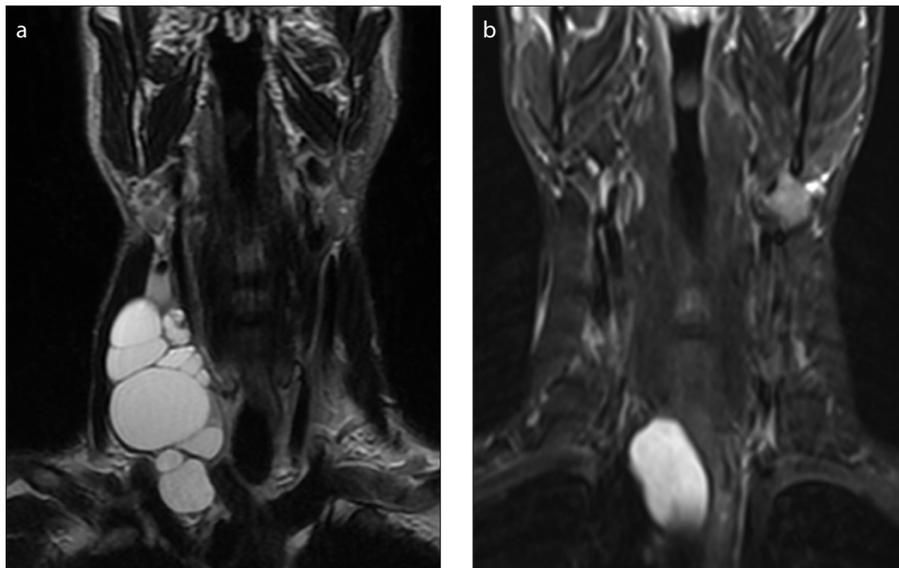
a, b. T2-weighted coronal image (a) demonstrates the malformation; T2-weighted coronal image (b) performed 18 months after treatment demonstrates disappearance of the treated malformation with stable residual lesion.
